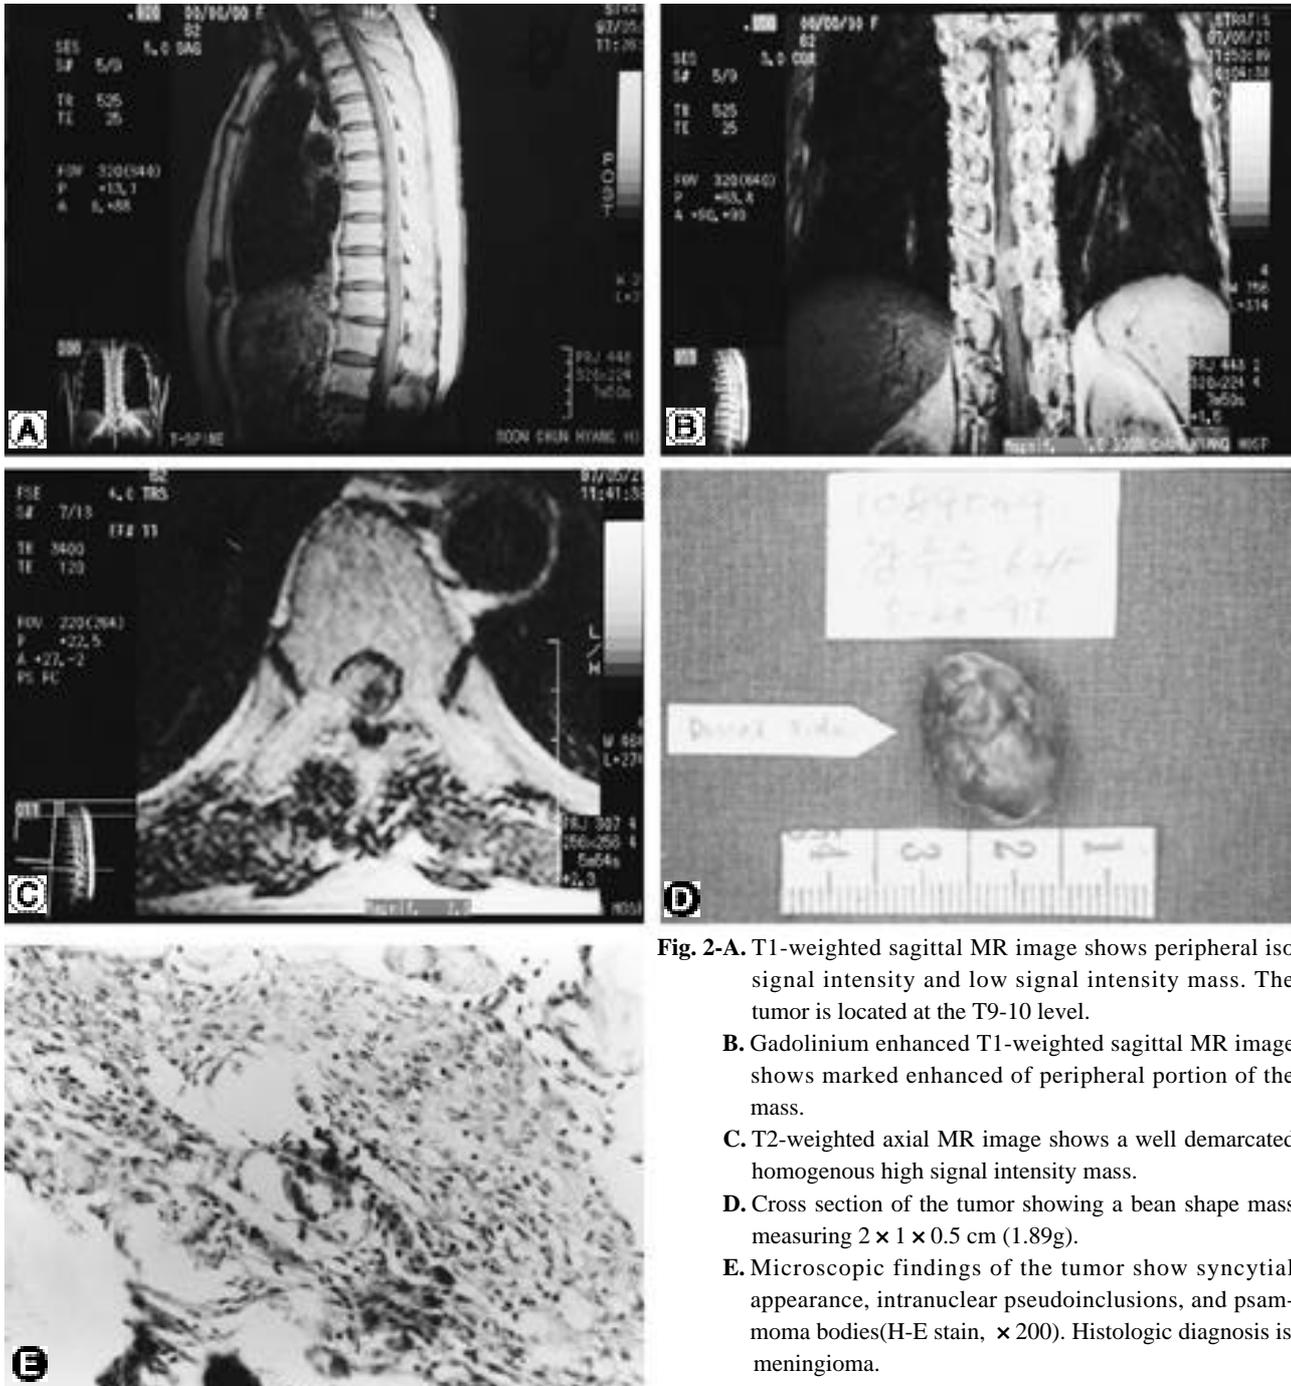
T1-weighted sagittal MR image shows peripheral iso signal intensity and low signal intensity mass. The tumor is located at the T9-10 level.
